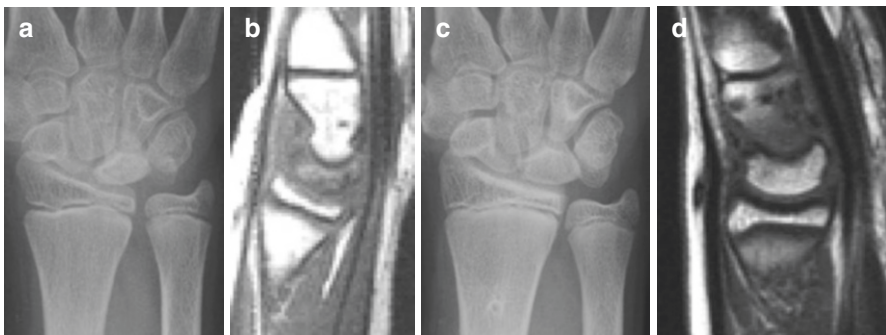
Kienböck's disease in an 11-year-old patient. (a) Plain radiograph representing sclerotic changes in the lunate. (b) Magnetic resonance imaging (MRI) of the diseased wrist. On a T1-weighted image, the lunate demonstrated diffuse low signal intensity. The patient underwent radial shortening osteotomy. Two years after the surgery, the lunate showed its normal contour radiographically (c). (d) MRI showed a normal lunate signal (diffuse high signal on a T1-weighted image)
